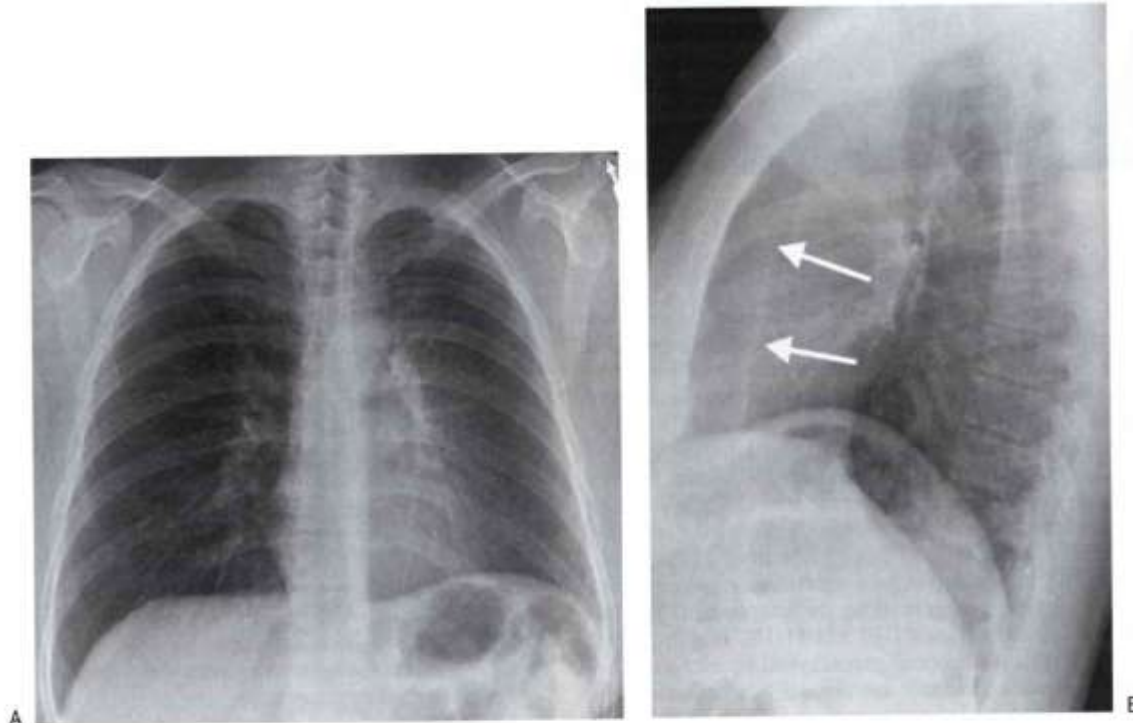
Left upper lobe collapse. A: PA chest radiograph of a 44-year-old man with a 6-month history of recurrent pneumonia shows elevation of the left hemidiaphragm, hazy opacity of the left hemithorax, and loss of the left heart border. B: Lateral view shows anterior displacement of the left major fissure (*arrows*) and increased retrosternal opacity. Bronchoscopic biopsy of a left upper lobe endobronchial mass confirmed the diagnosis of a bronchial carcinoid tumor as the cause of the left upper lobe collapse.
